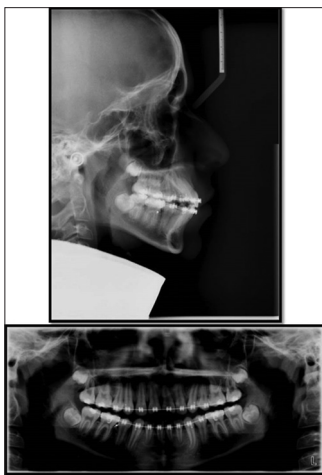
Near end-stage lateral cephalogram and orthopantomograph
